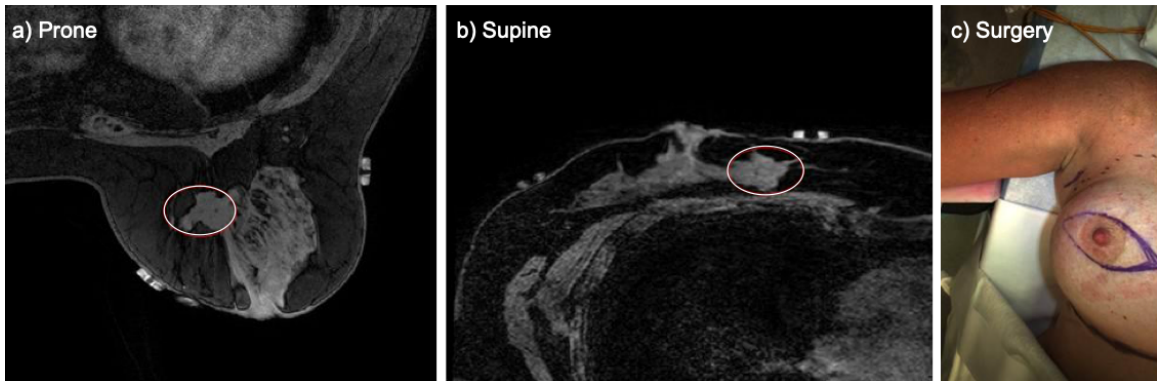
Deformation of a single patient's breast from (a) prone MR image of breast (b) supine MR image of breast and (c) surgical presentation. Tumor location is delineated with a circle in the MR images. Image reproduced from [60] with permission.
